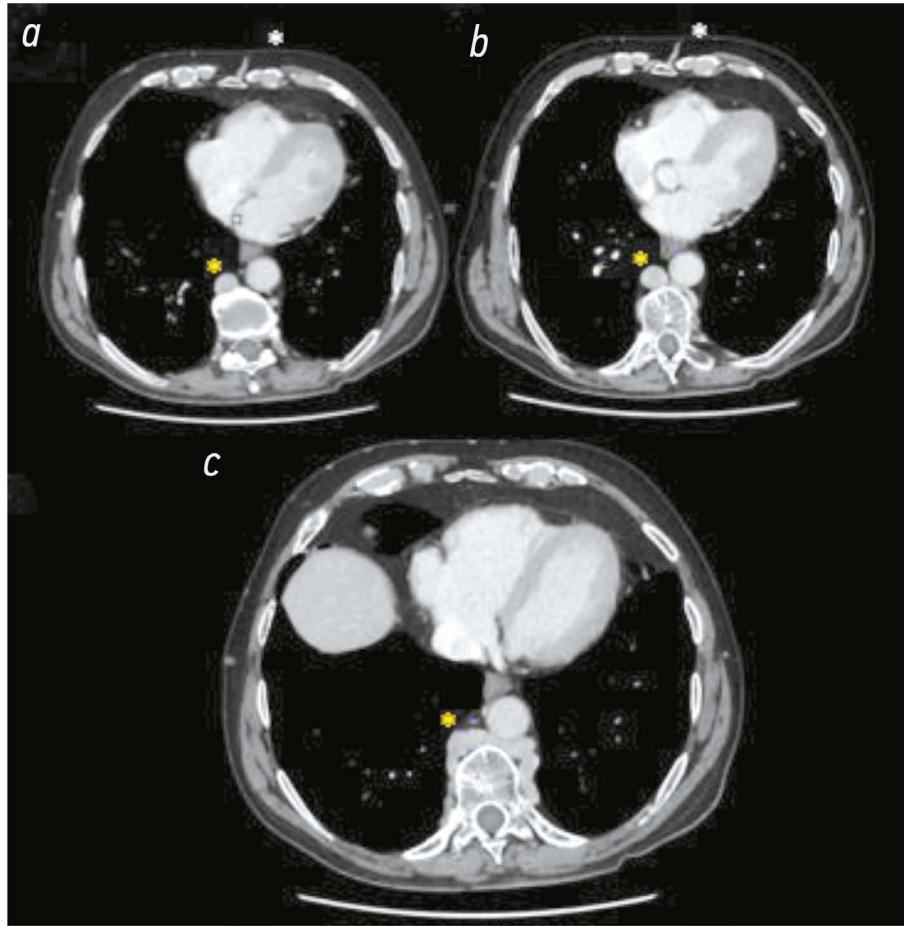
Computed tomography images of the axial section of the chest: the confluence with the hypertrophic azygos and hemiazygos veins is seen in all images at different levels (from upper to lower). In *a*) and *b*), the white asterisk marks the confluence of the collateral circles of the abdomen and chest.
